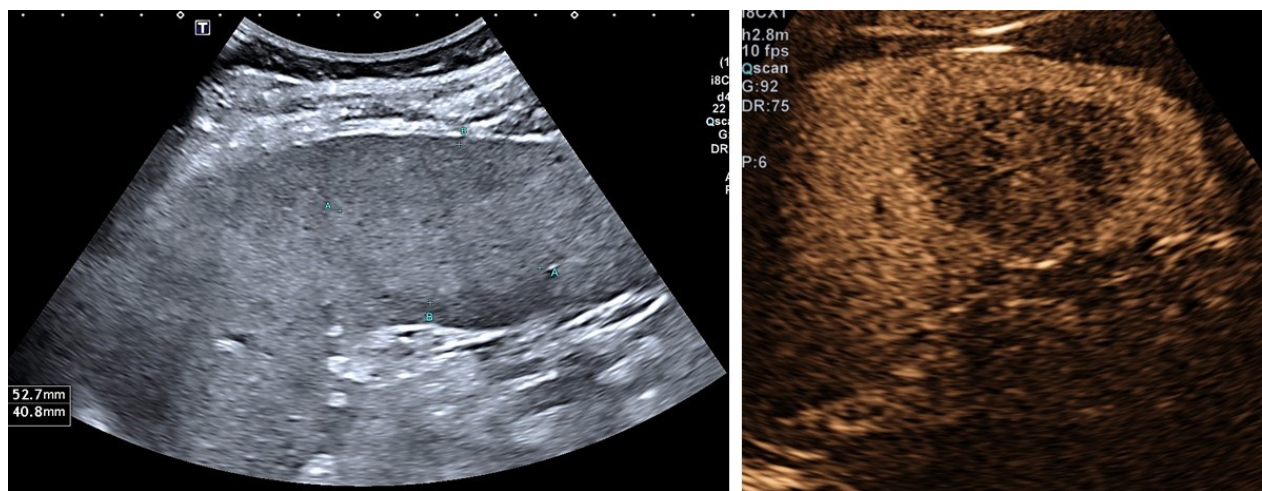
b.8. Splenic sarcoidosis. An isoechoic, on B-mode barely visible focal nodular lesion of the spleen parenchyma (5.3 cm, left panel). Following ultrasound contrast administration the lesion is hypoenhanced in comparison to the surrounding parenchyma, but retains contrast up to the late phase (right panel, 4 min after contrast administration)
